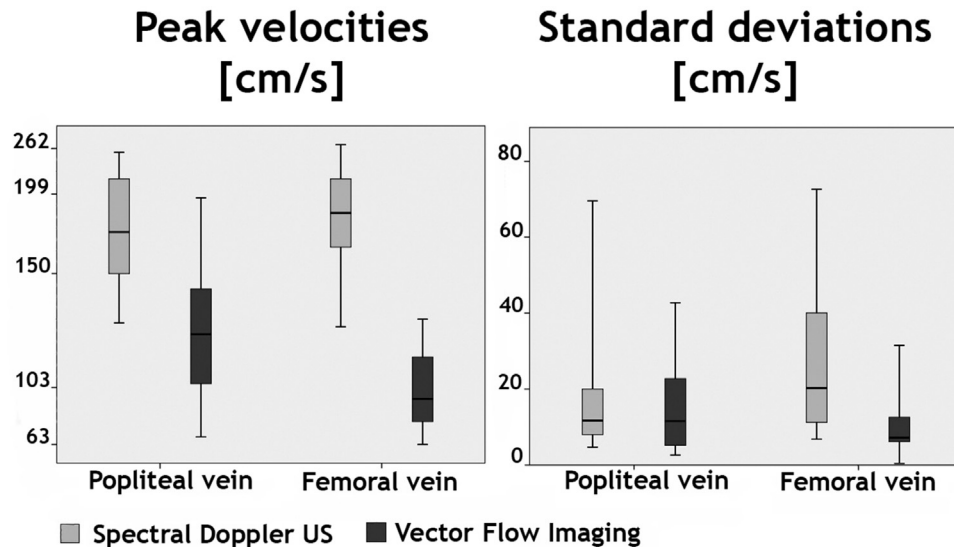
(Left) Boxplot of the peak velocities of the provoked antegrade flow pulses. The *light gray boxes* represent the velocities measured with spectral Doppler ultrasound (US), and the *dark gray boxes*, the velocities measured with vector flow imaging. (Right) Boxplot of the standard deviations of the three peak velocity measurements of each volunteer. The *light gray boxes* represent the standard deviations of the US measurements, and the *dark gray boxes*, the standard deviations of the vector flow imaging measurements.
